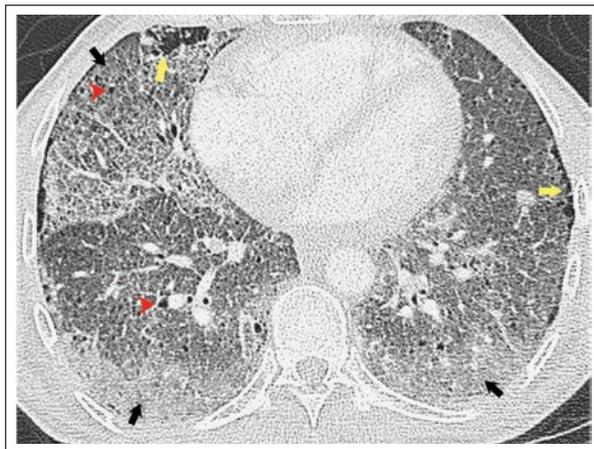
Alveolar hemorrhage associated with amyloidosis. Chest CT axial view showing multilobar ground glass (black arrows), bilateral pulmonary cysts (red arrowheads), and paraseptal emphysema (yellow arrows).
